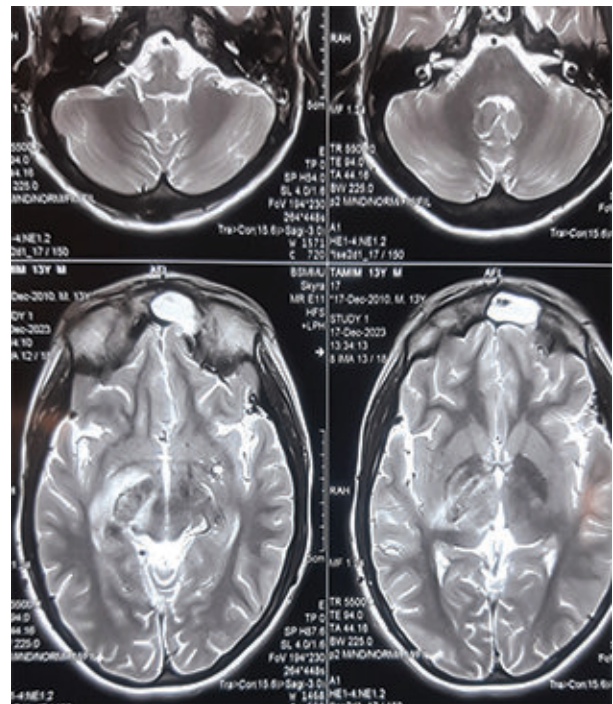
Multi-axial T2 sequence MRI of brain showing mixed intensity lesion in right thalamus, midbrain and part of capsuloganglionic area.
